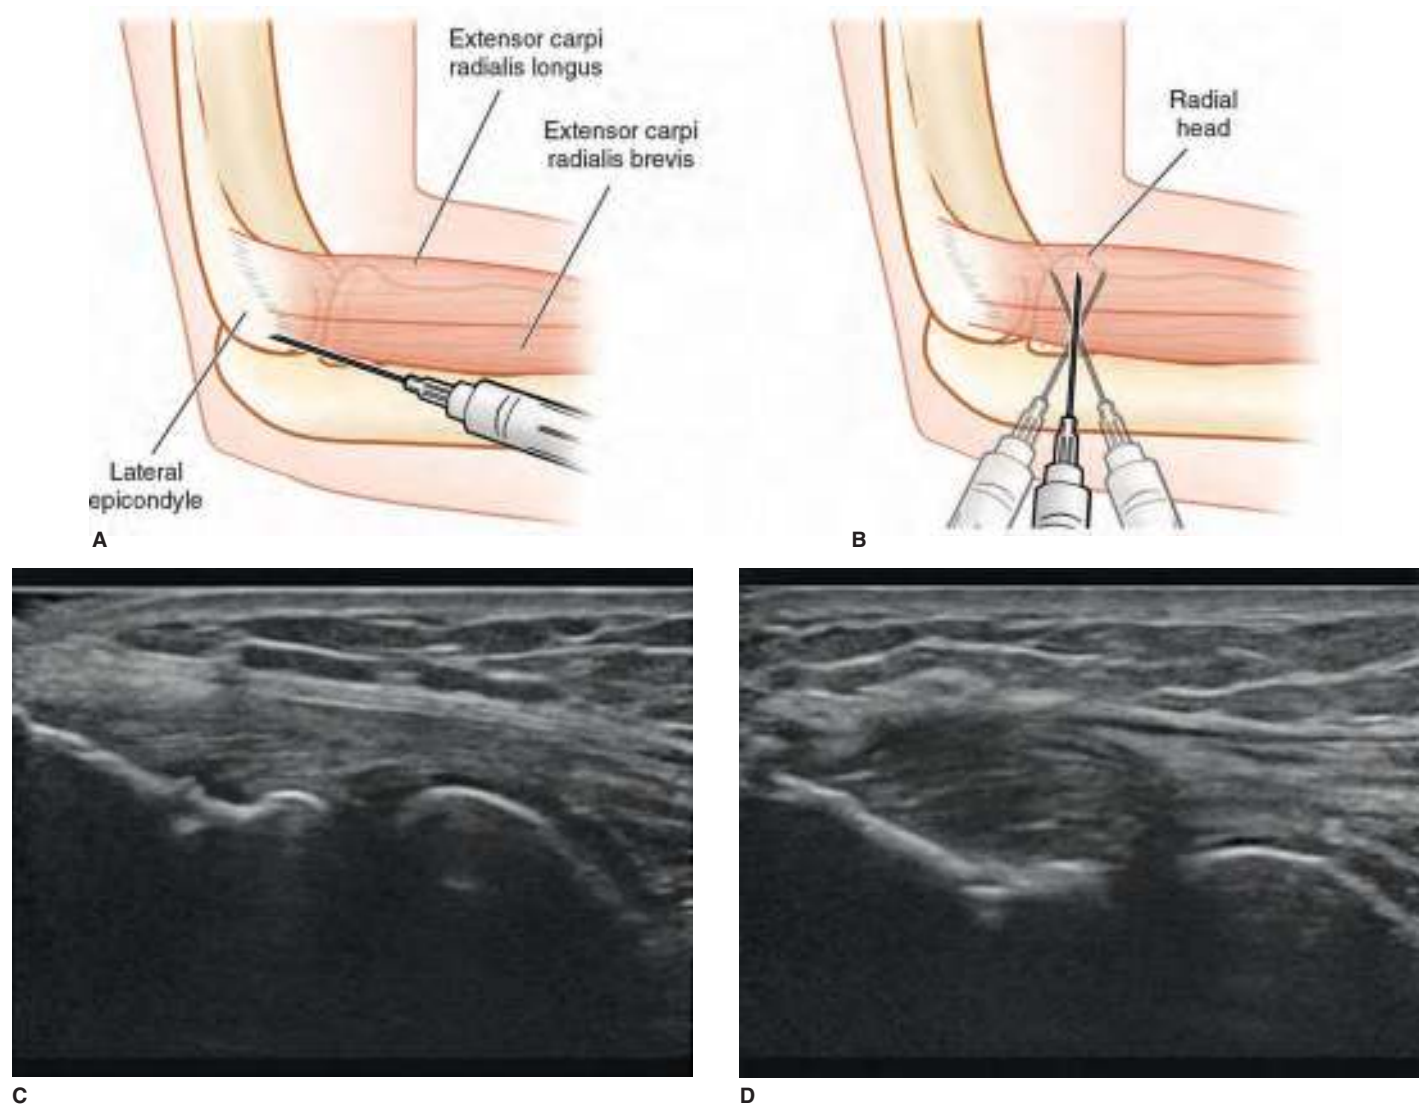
Injection for lateral epicondylitis. A. The needle is inserted at the level of the radial head and advanced to the base of the lateral epicondyle. B. The needle is redirected in a fan-like pattern over the muscle bellies. C. Normal US image. D. Thickened extensor tendons at insertion. (US images courtesy of www.ultrasoundcases.info.)
